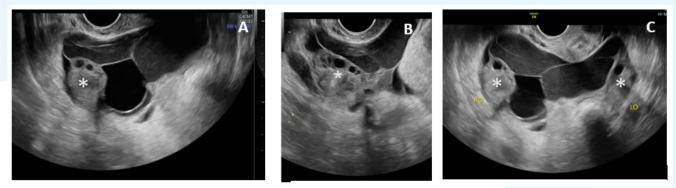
Ultrasound of right adnexa. A. Sagittal US gray scale right adnexa demonstrates a multilocular cyst. The asterisk (\*) denotes the right ovary. B. Transverse US gray scale right adnexa demonstrates a multilocular cyst. The asterisk (\*) denotes the right ovary. C. Transverse US gray scale image of the pelvis with a multiloculated cyst between the ovaries as denoted by the asterisk (\*, \*).
